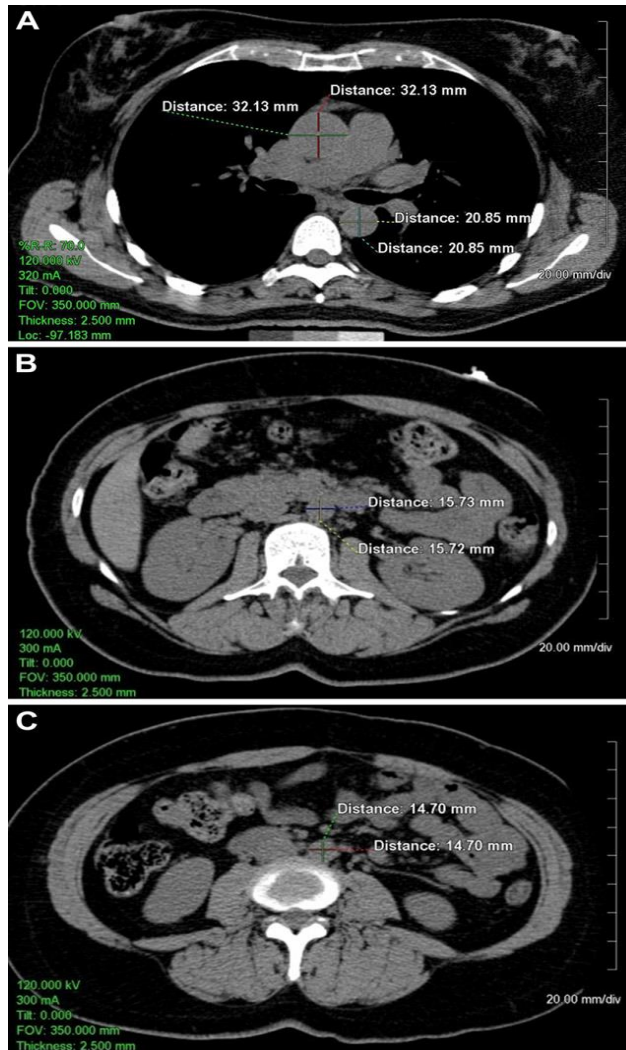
Axial non-contrast-enhanced computed tomographic images of the AA (measurements in upper part of figure) and DTA (measurements in lower part of figure) at the level of the right pulmonary artery, (B) the IRA 5 cm above the aortoiliac bifurcation, and (C) the LAA just above the aortoiliac bifurcation. The images demonstrate sample measurements of the aorta from outside wall to outside wall in the anteroposterior and transverse planes. (Rogers et al 2013)
